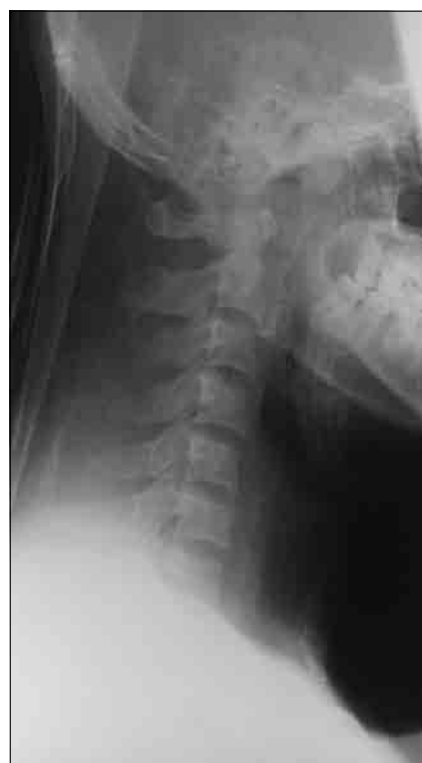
Lateral cervical spine X-ray taken with rigid neck collar 2nd day posttrauma in intensive care unit.
